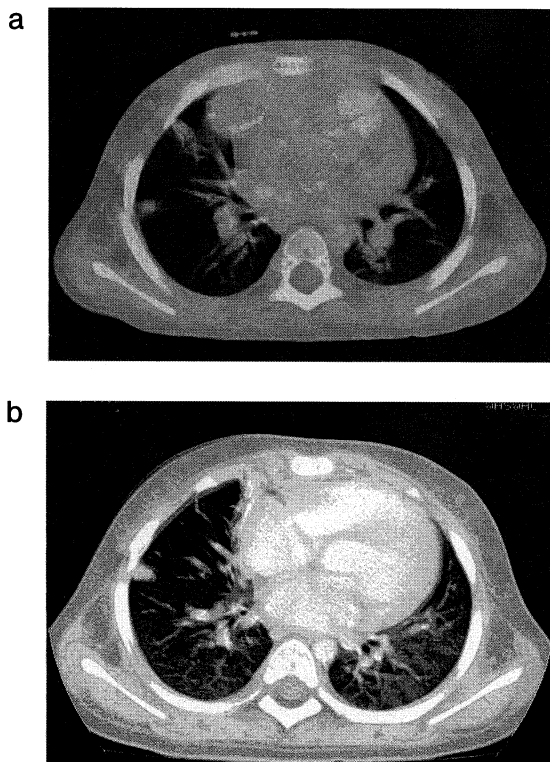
Computed tomography scan on the 27th hospital day (a) reveals a nodule with central lucency. Another computed tomography section on 50th hospital day (b) shows a scar.
